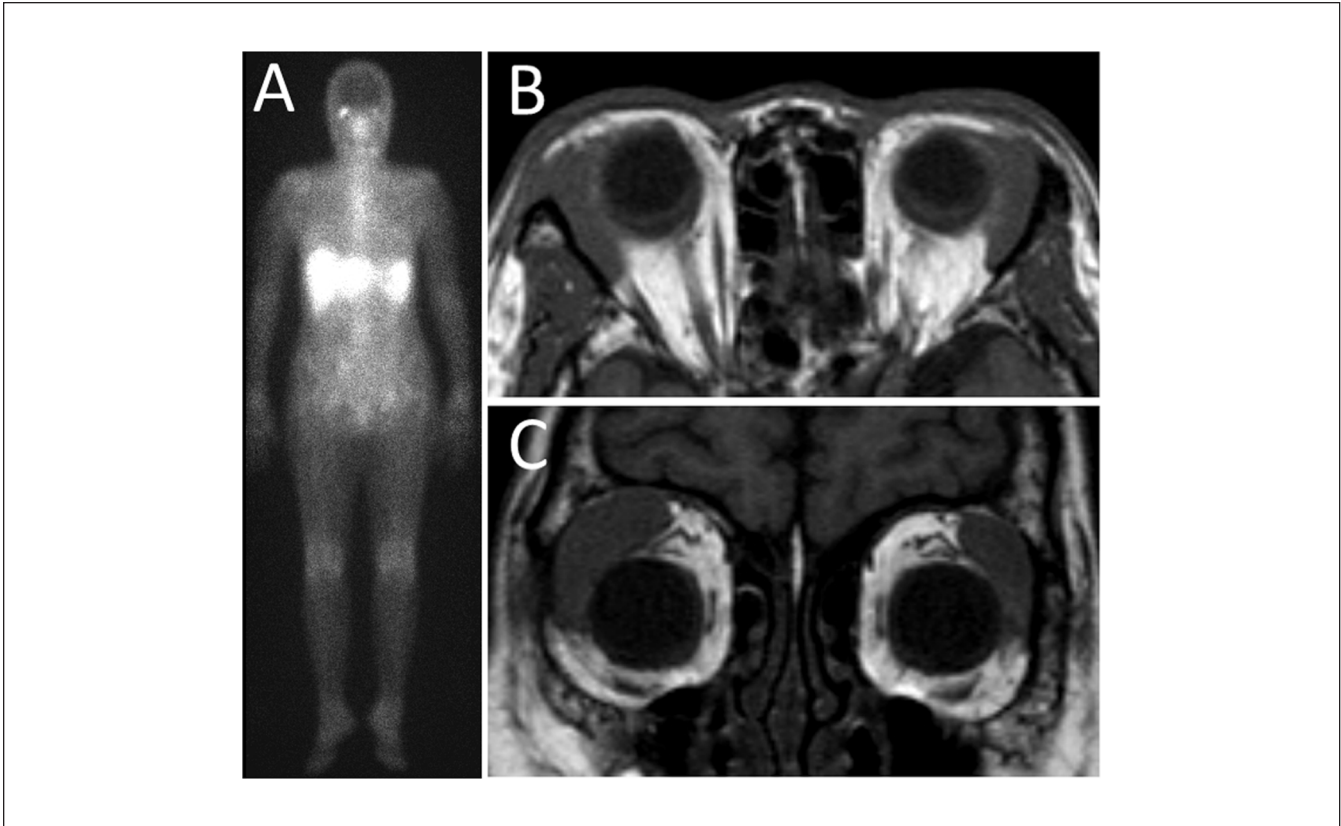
Gallium-67 scintigraphy (A), showing high uptake in bilateral lacrimal glands, and magnetic resonance imaging, showing bilateral lacrimal gland masses in axial (B) and coronal section (C) at the initial visit at the age of 63 years.
